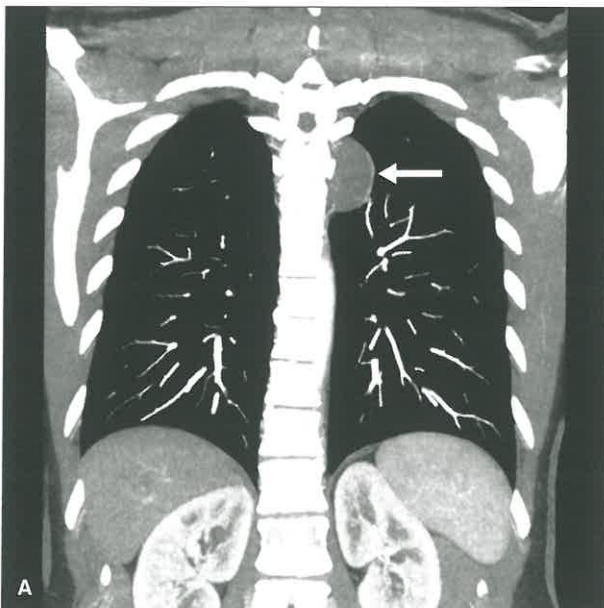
Schwannoma. A: Contrast-enhanced coronal maximum intensity projection CT in an asymptomatic 39-year-old woman demonstrates a left upper paravertebral soft tissue mass (arrow). B: Axial T1-weighted fat saturated post contrast MR shows enhancement of the lesion. CT-guided biopsy confirmed a schwannoma.
